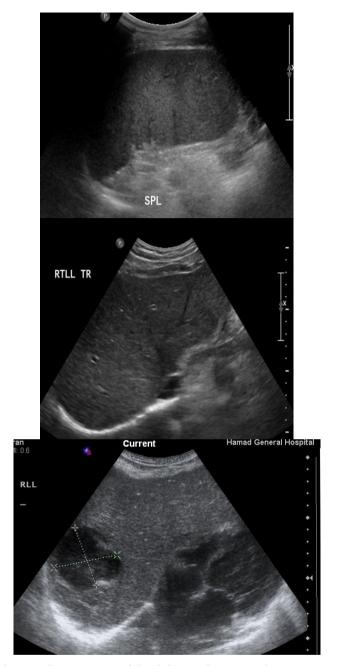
Ultrasound examination of the abdomen show normal appearance of the right lobe of the liver and spleen with no collection or abscess formation. Ultrasound examination of the abdomen show complex well-defined area in the right lobe of the liver measuring 9×409 c.
